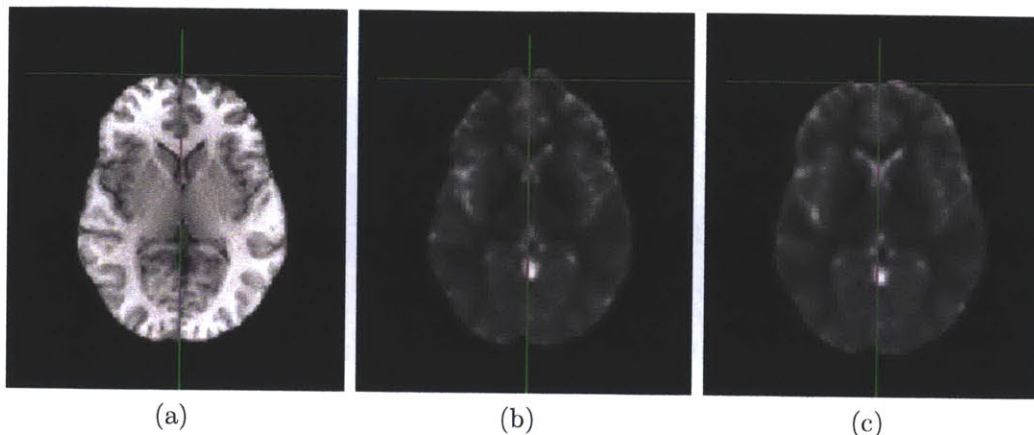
Fieldmap-based Distortion Correction. A structural MRI (a) and distorted EPI (b) show substantial differences in shape especially in the anterior region of the brain. Correcting the distortion using an acquired fieldmap results in the EPI shown in (c) and allows accurate registration of the corrected EPI to structural MRI.
